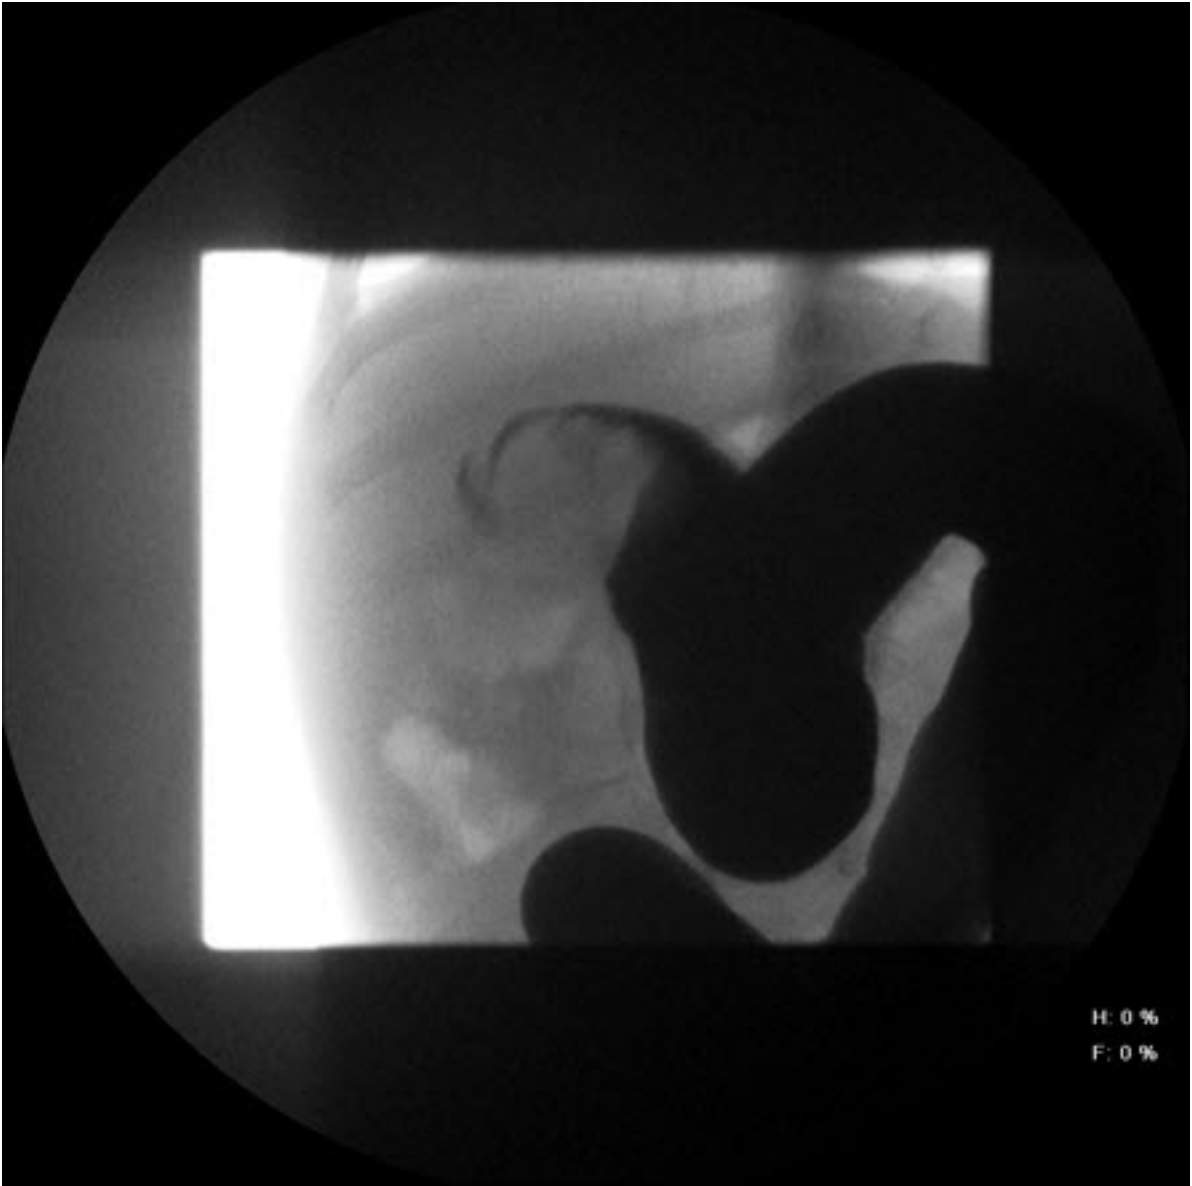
Intussusception: Site of intussusception as revealed by abdominal x-ray, showing the meniscus
